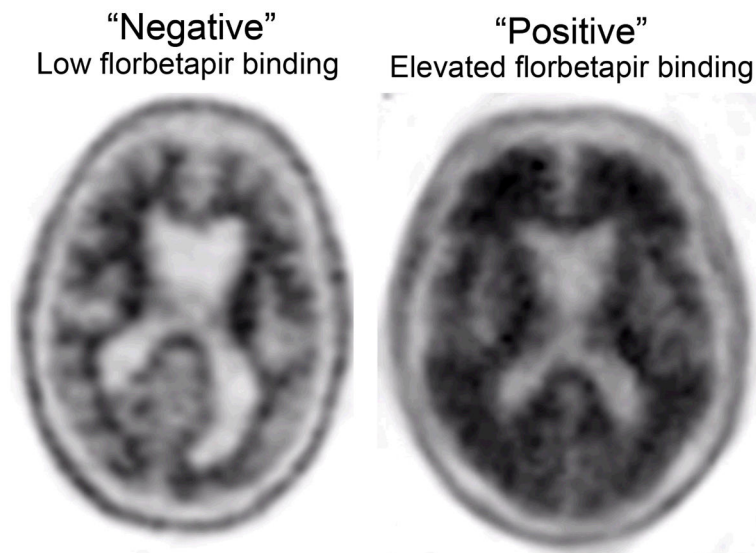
Assessing amyloid deposition using florbetapir (Amyvid™, <http://www.amyvid.com>). The axial PET image on the left shows normal preserved gray-white contrast with the cortical radioactivity less than the adjacent white matter (amyloid ‘negative’ scan). The axial PET image on the right demonstrates areas of decreased gray-white contrast with increased cortical radioactivity that is comparable to the radioactivity in the adjacent white matter (amyloid ‘positive’ scan). The florbetapir scan on the right was acquired on an MCI individual who clinically progressed to dementia with high biomarker probability of AD, as supported by this amyloid positive scan and evidence of neuronal injury on structural MRI (see Figure 1).
